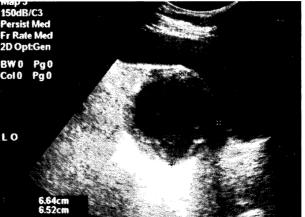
Cystic appearance of the abscess. 1a. Abdominal ultrasonography. 1b. Transvaginal ultrasonography in the same patient.
